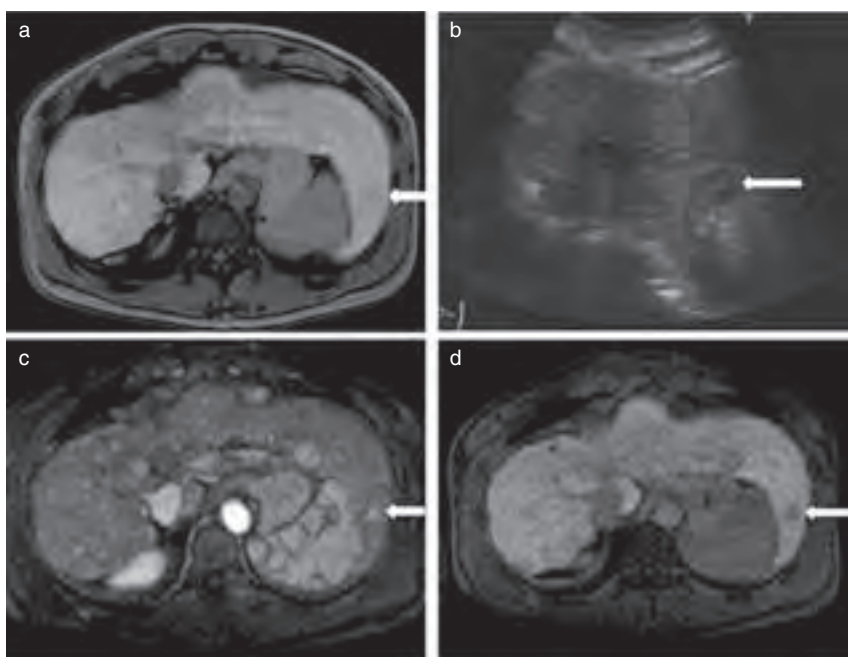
Imaging findings of the nodule in S2. gadolinium-ethoxybenzyl-diethylenetriamine pentaacetic acid (Gd-EOB-DTPA)-enhanced magnetic resonance imaging (MRI) in 2008 shows the nodule as isointense in the hepatobiliary phase (arrow) (a). In 2011, B-mode ultrasonography reveals a hypoechoic nodule (arrow) (b); Gd-EOB-DTPA-enhanced MRI reveals a hypervascular nodule in the arterial phase (arrow) (c), but a defect in the hepatobiliary phase (arrow) (d).
